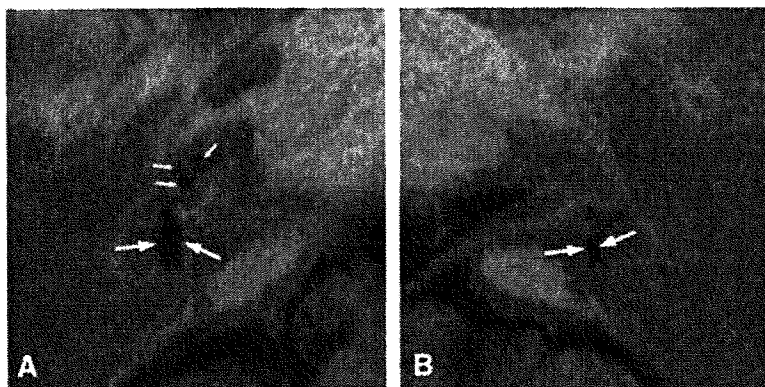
3D-real IR MRI of case 3. A, right ear; B, left ear. In A, short arrows indicate endolymphatic hydrops in the basal and upper turns of the cochlea (black areas). In A and B, long arrows indicate endolymphatic space in the vestibule. The endolymphatic space is clearly larger in A than in B.
